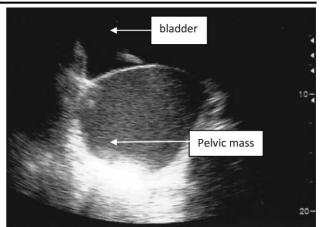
Picture of Pelvic ultrasound prior to urinary catheterization (Transverse view).
